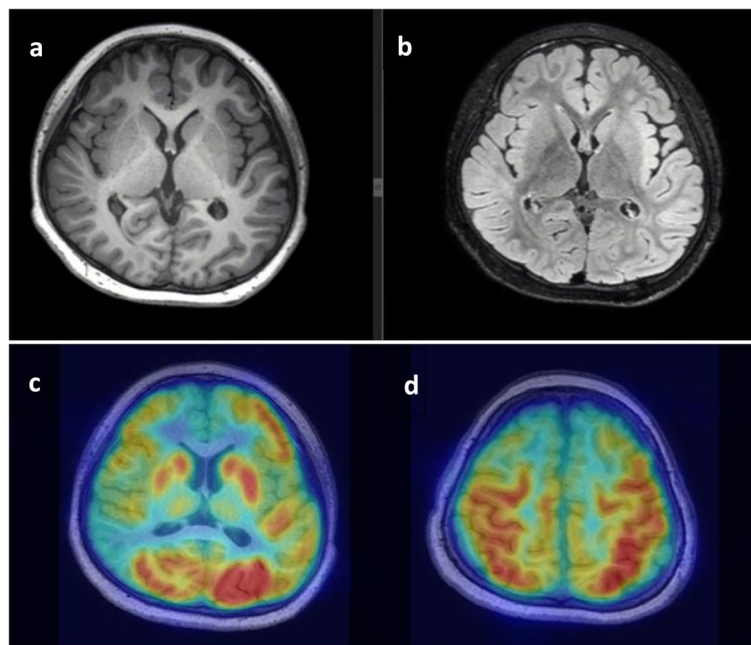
Brain imaging: MRI scan revealed mild diffuse cerebral atrophy and focal cortical dysplasias in the right temporal lobe on T1-weighted (a) and FLAIR (b) images. PET-MRI showed hypometabolism in the right temporal-parietal area (c) and the bilateral frontal lobes (d)
